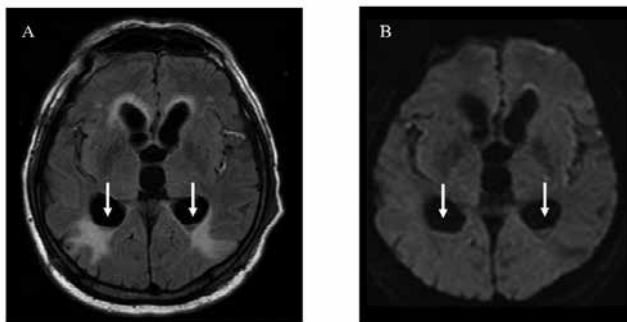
Neuroimaging findings in the present case. MRI shows high-signal deposits (arrows) in the bilateral ventricles on axial (A) FLAIR and axial (B) DWI images.
